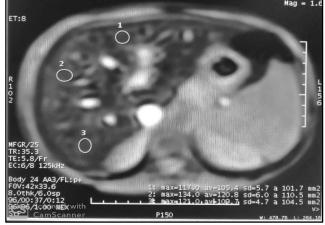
Hepatic T2* of child with beta thalassemia. An 8 years old male child diagnosed with thalassemia major disease. Clinically, the patient exhibited hepatomegaly, no splenomegaly and anemia on regular blood transfusion every 30 days. Laboratory investigation revealed elevation in serum ferritin level 357 ng/ml [normal range: 21.8-247.6 ng/ml] along with normal bilirubin 0.8 mg/dl [normal range: 0.1-1.2 mg/dl] and normal albumin 4.2 mg /dl [normal range: 3.4-5.4 mg/dl]. Notable, normal AST 24 IU/L [normal range: 10-34 IU/L] and normal ALT 36 IU/L [normal range: 10-44 IU/L]. MRI [T2*] performed on liver resulting in elevated T2* [111 MS] which means LIC 6.02 ng/g denoting mild hepatic iron overload.
